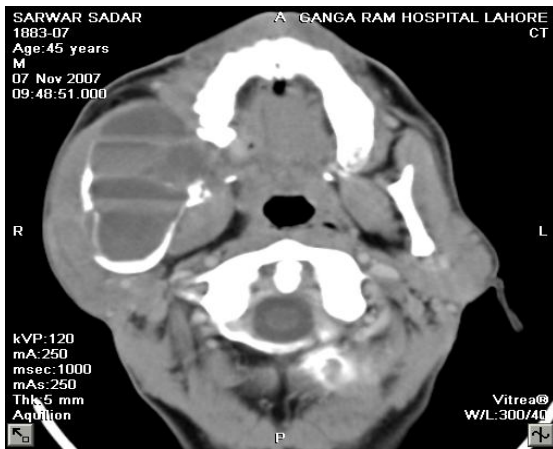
Axial postcontrast CT image showing multilocular cystic mass in the right ramus of mandible with fluid-fluid levels and extensive thinning/destruction of the overlying bony cortex.
